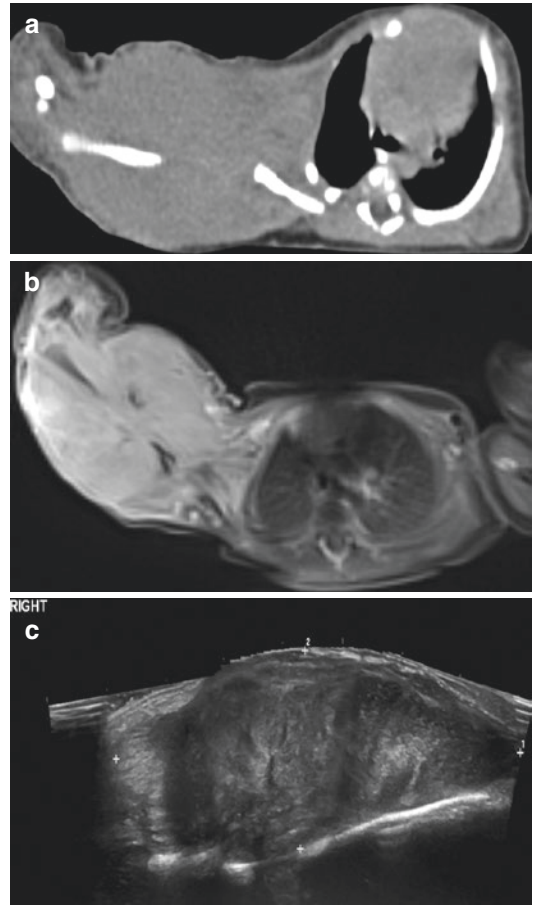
This right upper limb soft tissue lesion is poorly delineated on non-contrast CT (a) but much better seen and assessed on both MRI (b) and ultrasound (c)
